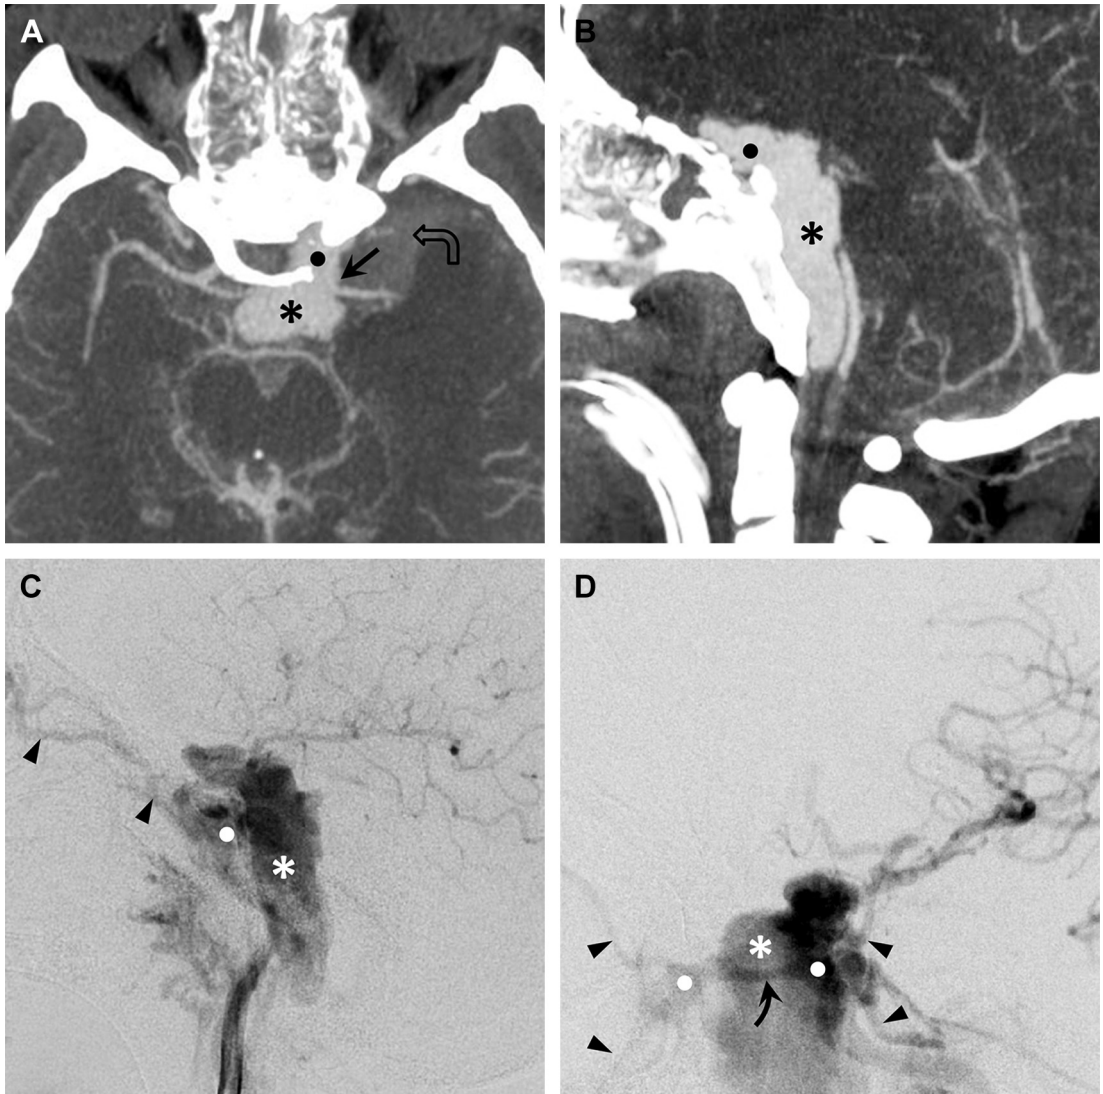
ICA transection, free contrast extravasation, and carotid-cavernous fistula. (A) Axial and (B) sagittal MIP images from a CTA demonstrate extensive dilatation of the left cavernous sinus (●) as well as extravasation of contrast into a semi-contained prepointine hematoma (*asterisk*) and subarachnoid space (*curved open arrow*). The left ICA (*arrow*) is not well seen due to the ICA transection. (C) Lateral and (D) anteroposterior angiogram images confirm free extravasation of contrast into the prepointine cistern (●), early entry of contrast into the cavernous sinuses (*asterisk*), and filling of the superior and inferior ophthalmic veins (*arrowheads*). Note that contrast fills both of the cavernous sinuses via an anterior intercavernous vein (*curved arrow*).
